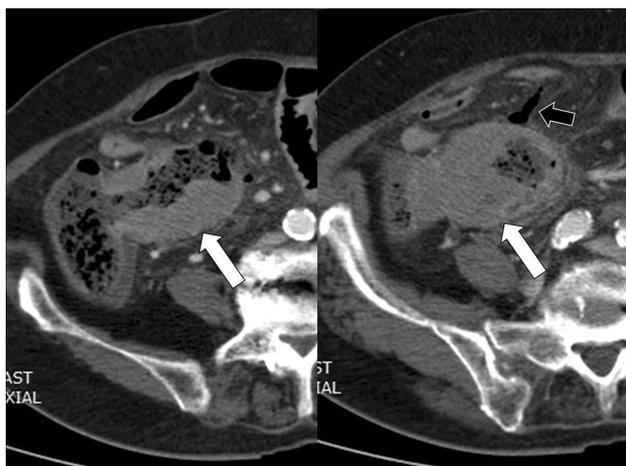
A 91-year-old woman with abdominal pain. Serial CT images show segmental, annular, low-attenuating wall thickening of the terminal ileum (arrows). Despite annular wall thickening, bowel obstruction was not noted. Additionally, perienteric free air (black arrow) and small fluid collection (not shown), indicating bowel perforation, were observed. After right hemicolectomy, diffuse large B-cell lymphoma with serosal perforation arising from the terminal ileum was confirmed
